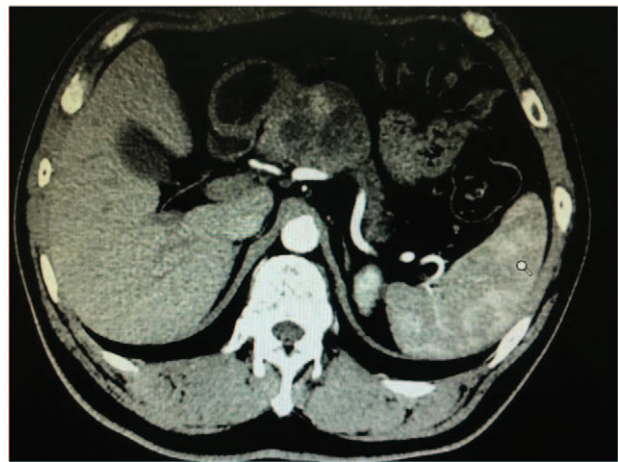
Enhanced CT scan of the MCN (artery phase). CT=computed tomography, MCN=mucinous cystic neoplasm.
